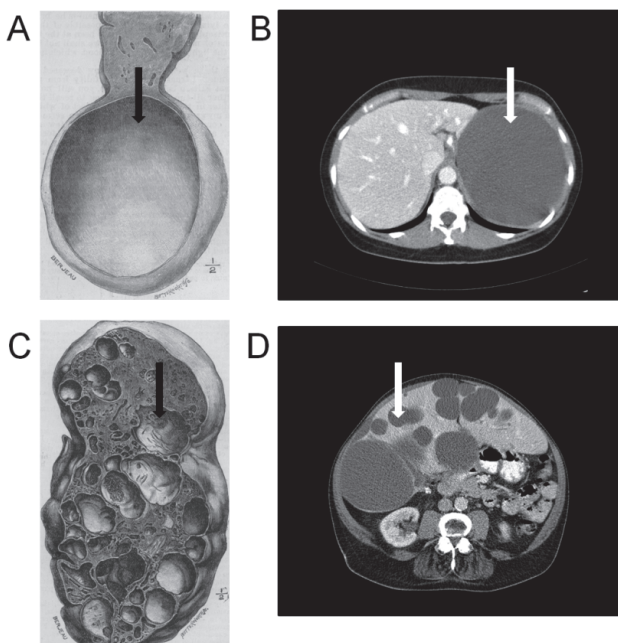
Simple hepatic cyst and polycystic liver. (A) Protruding hepatic cyst (black arrow) from the free border of the liver.¹¹ (B) Axial CT scan of a large hepatic cyst indicate by a white arrow. (C) Liver section presenting multiple large cavities. (D) Axial CT scan of a PCLD patient.
